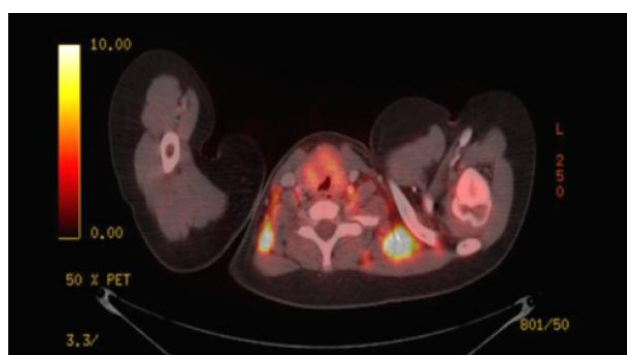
PET CT (post chemotherapy): good response in the primary (SUV Max 6.22).
